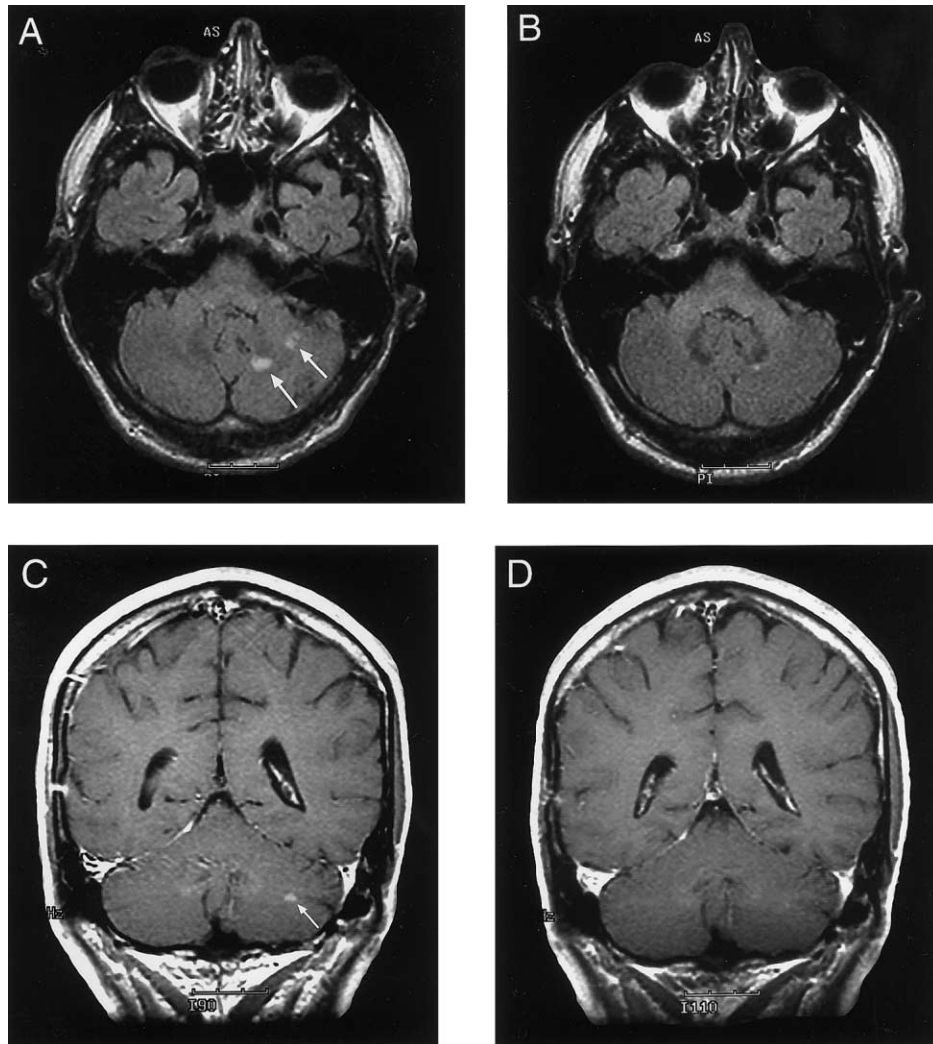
A, Gadolinium-enhanced, T1-weighted MRI (axial cut). MRI reveals 2 cerebellar lesions that enhance with gadolinium. B, Significant resolution of left cerebellar lesions. C, Coronal MRI with gadolinium demonstrating a left cerebellar lesion. D, Significant tumor shrinkage after 6 months of therapy.
